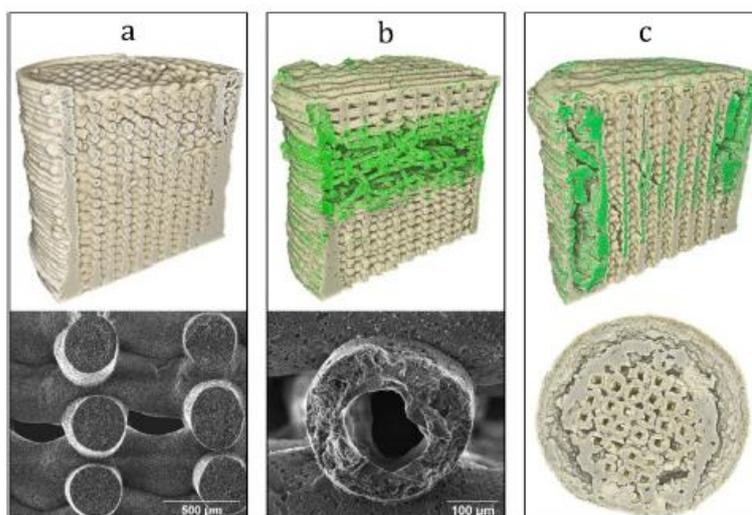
3D reconstruction of X-ray tomographic slices and SEM images for the characterisation of internal structures.¹
